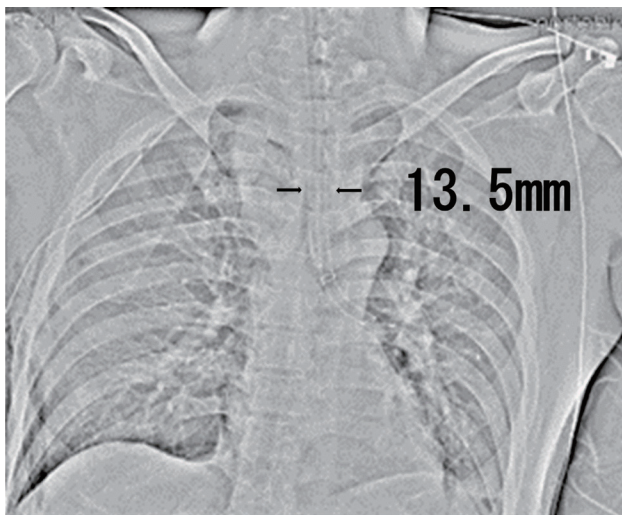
Radiograph after operation, supine position.
